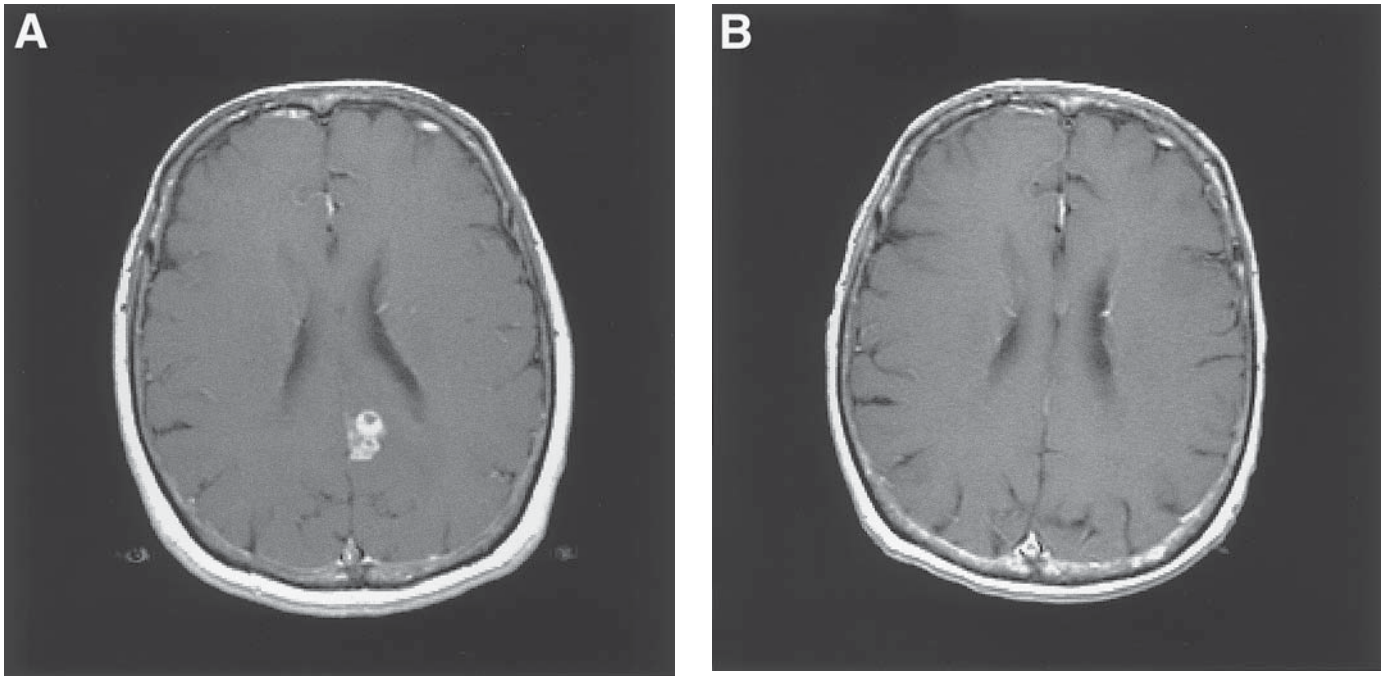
(A) Preradiosurgery. T1 weighted, postgadolinium MRI scan of a patient with renal cell carcinoma. Single left occipital metastasis. (B) Postradiosurgery. T1 weighted, postgadolinium MRI scan of the same patient 12 wk after radiosurgery. There is no evidence of the tumor.
